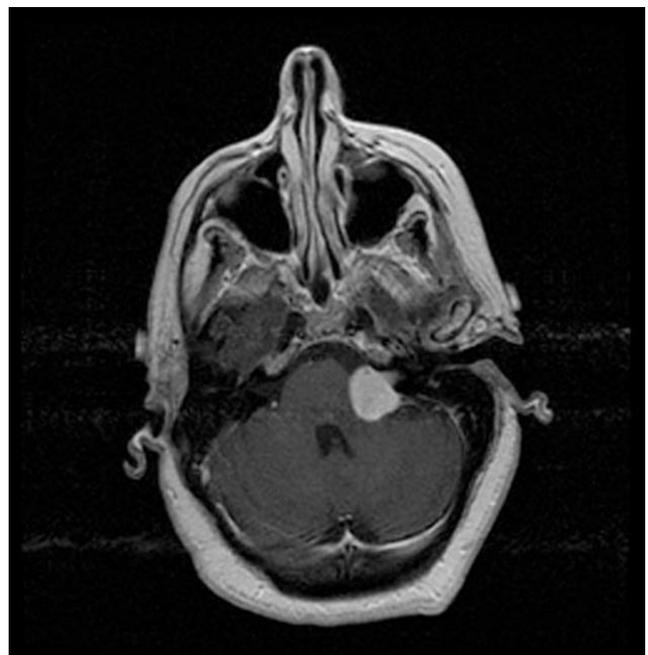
Axial Gadolinium enhanced MR image shows an enhancing Acoustic neuroma in left CP angle extending into left internal acoustic meatus.
